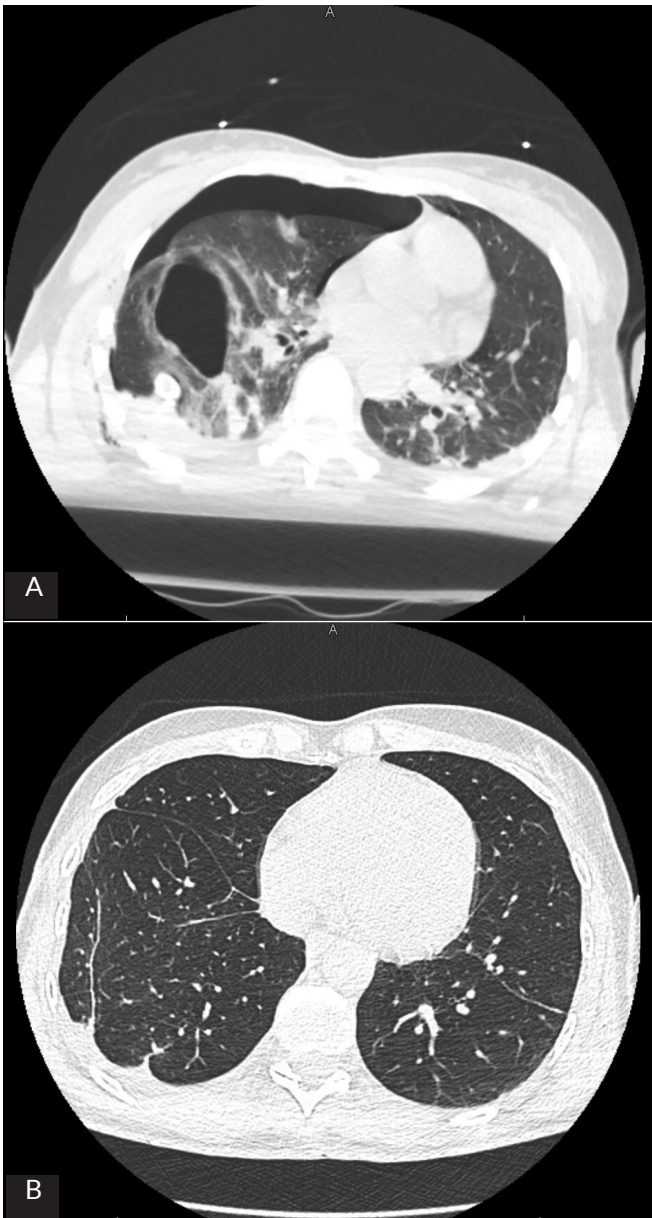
Case 1. Computed tomography findings. A. Preoperatively. B. Postoperatively
